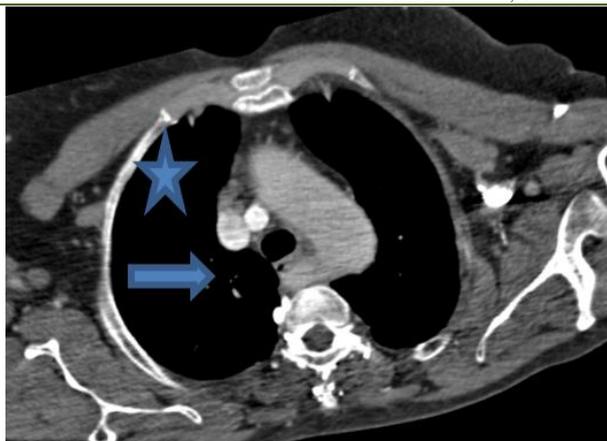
Post contrast Computed Tomography – Angiography axial image An aberrant right subclavian artery (arteria lusoria), (bleu arrow) which originates from the aortic arch (bleu star), crosses the midline between the spine and the esophagus
